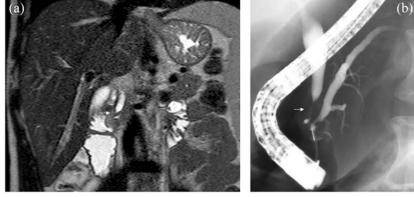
A 36-year-old man with recurrent abdominal pain and fever. AIDS had been diagnosed 12 years previously and treated episodically with antiretroviral drugs. Coronal MR T2-weighted image (A) and endoscopic cholangiogram (B) show focal distal common bile duct stricture (arrow) with mild upstream dilatation. Diagnosis was AIDS-associated cholangiopathy [1].
